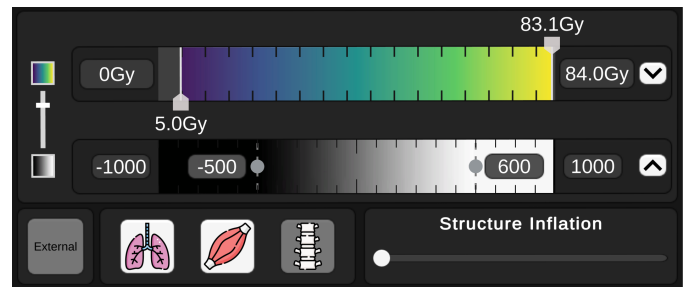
The Visualization Shortcuts Palette floating above the non-dominant hand includes the Dose Range Slider (colored gradient), CT Range Slider (gray-scale gradient), and toggles for rendering of anatomical context (bottom icons).
